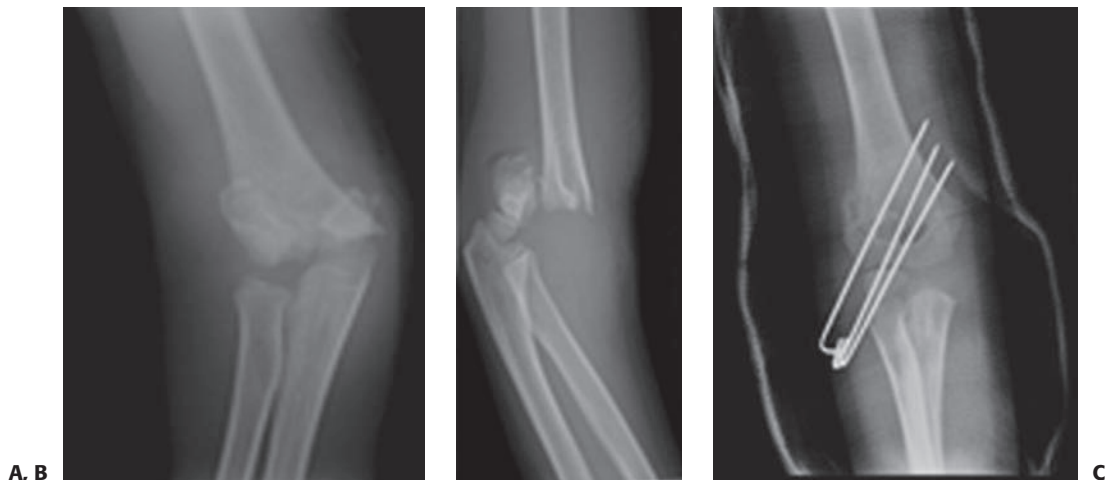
A: AP radiograph of a type III fracture in a 6-year-old boy. B: Lateral view. C: AP radiograph 3 weeks postoperative.
